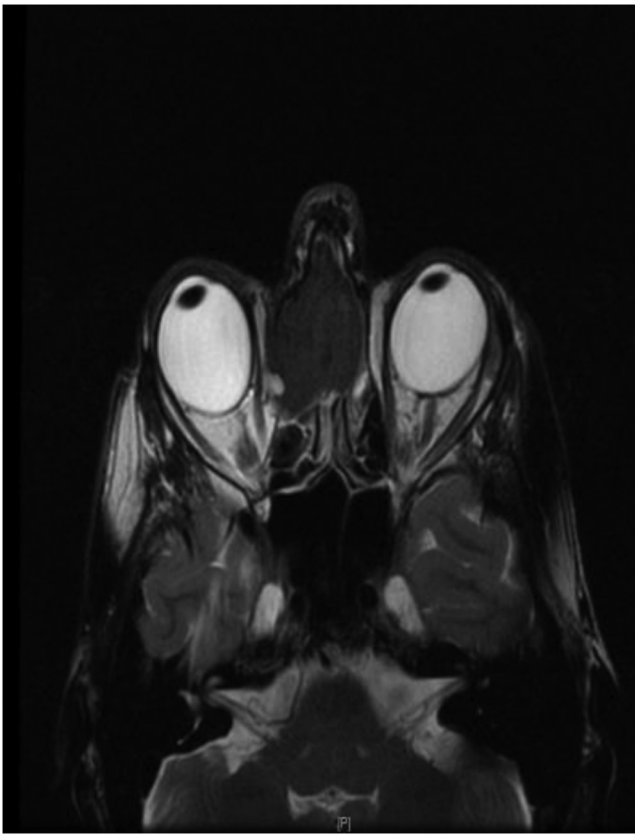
The well-demarcated bony wall which is hypointense to soft tissue on axial MRI T2-weighted image. B: MRI images demonstrate right ethmoid lesion with mass effect and ethmoid air cells primary tumor.
